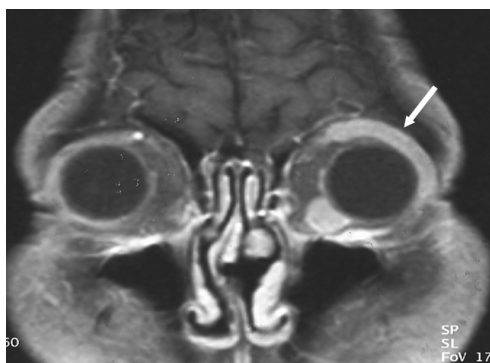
A malignant lymphoma in a 41-year-old woman. A gadolinium enhanced T1-weighted coronal image shows an elongated soft tissue mass (arrow) along the superior lateral aspect of the left eye globe. This lesion shows homogeneous and strong enhancement. Another enhancing nodule is noted at the inferior medial aspect of the left eye globe.
